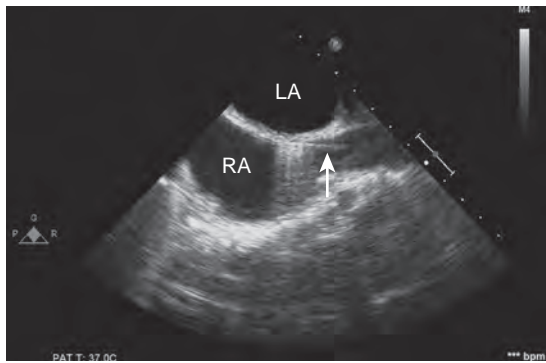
The midesophageal bicaval transesophageal echocardiography view allows confirmation of the guidewire position in the right atrium (arrow). LA, Left atrium; RA, right atrium.
